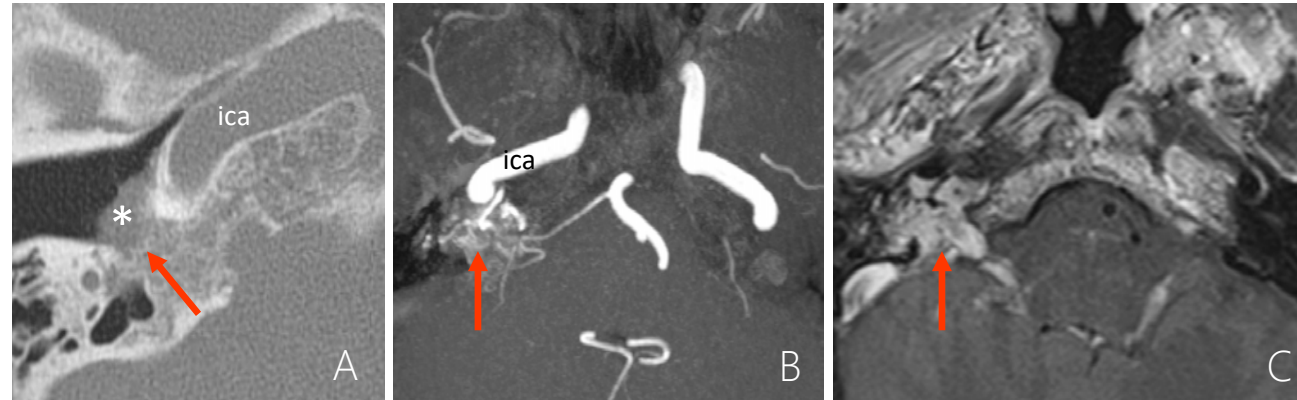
Axial CBCT image shows a hypotympanic lesion (asterisk) along the promontory associated with petrous bone erosion (arrow). Axial MR angiography sequence (TOF, B) and T1W contrast-enhanced image (C) show a strongly enhancing mass with important neovascularization (arrows) partly arising from the internal carotid artery (ica).
